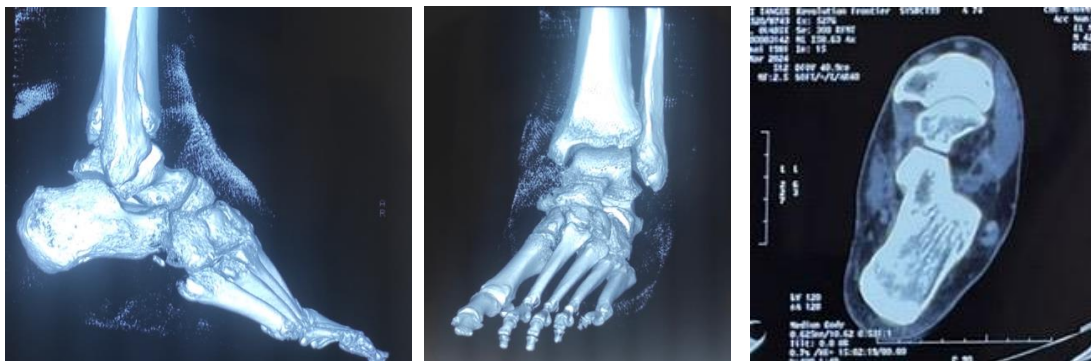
CT scan with reconstruction demonstrates non-displaced small fracture fragments of the talar bone with congruent ankle and subtalar joints.
